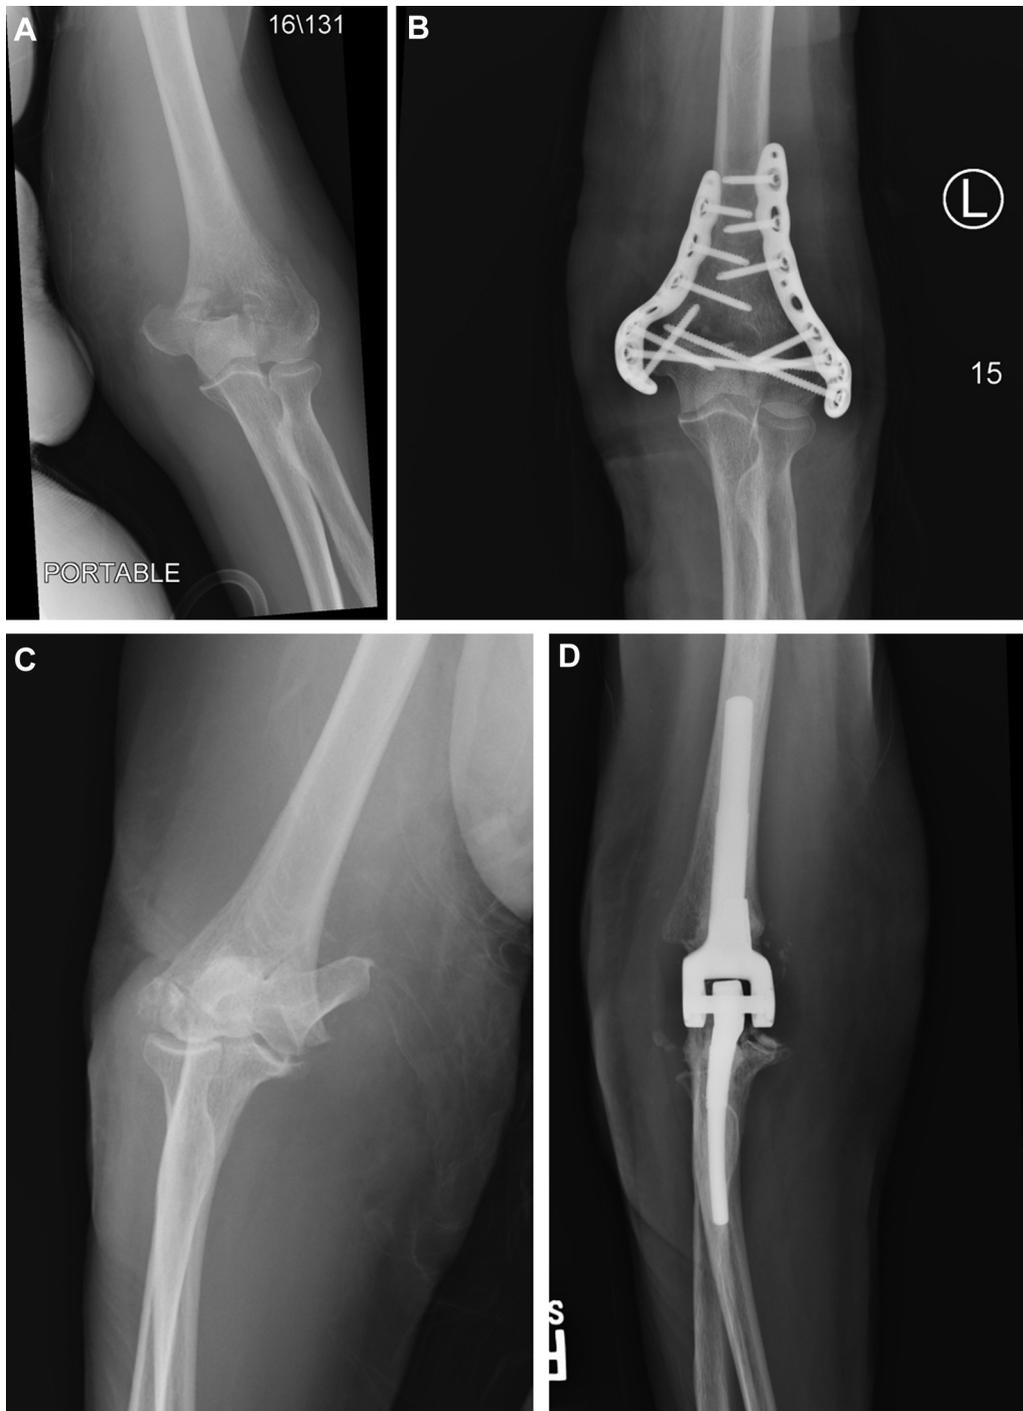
Open reduction–internal fixation and total elbow arthroplasty for treatment of distal humeral fractures in elderly patients. Representative radiographs are shown for patients who underwent either open reduction–internal fixation with bi-columnar plating (A, B) or total elbow arthroplasty with the Coonrad-Morrey semiconstrained implant (C, D) following a comminuted intra-articular distal humeral fracture.
